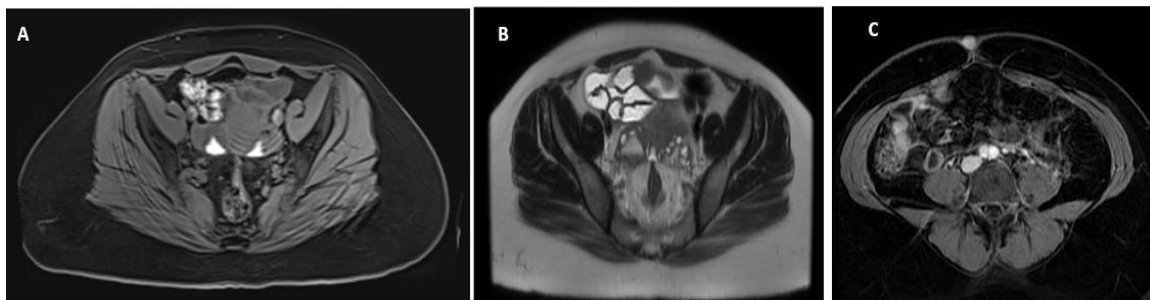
MRI (A) Axial precontrast T₁ WI, and (B) Axial T₂ WI shows bilateral ovarian endometrioma and deep pelvic endometriosis. (C) Axial T₁ post contrast show umbilical small hemorrhagic lesion represent endometriosis.
